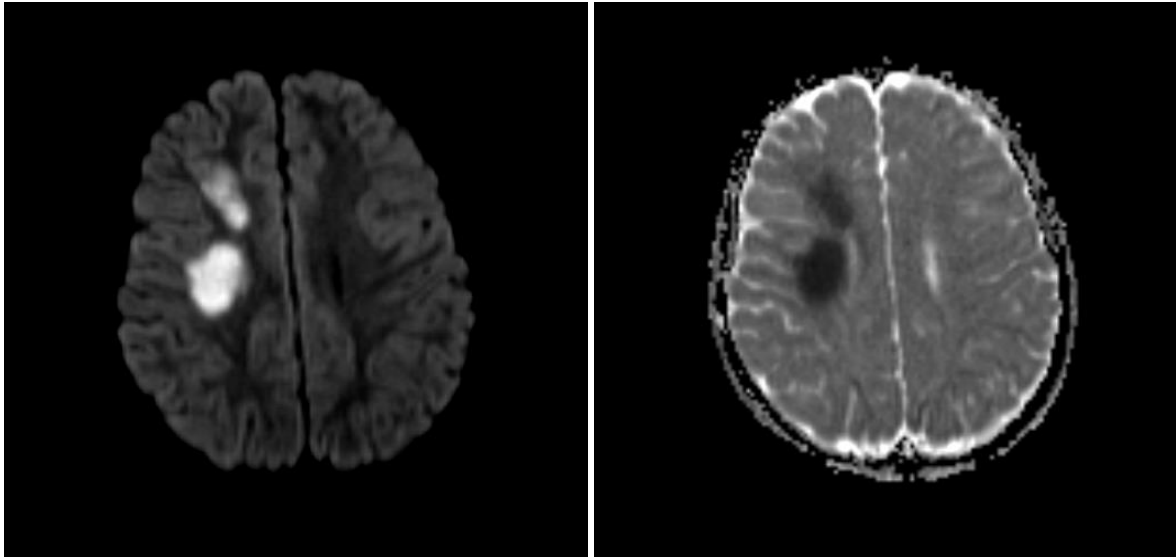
MRI image demonstrating increased b1000 diffusion signal (top) and diffusion restriction (bottom) in the right frontal centrum semiovale indicating an acute infarct (in the right middle cerebral artery territory).
